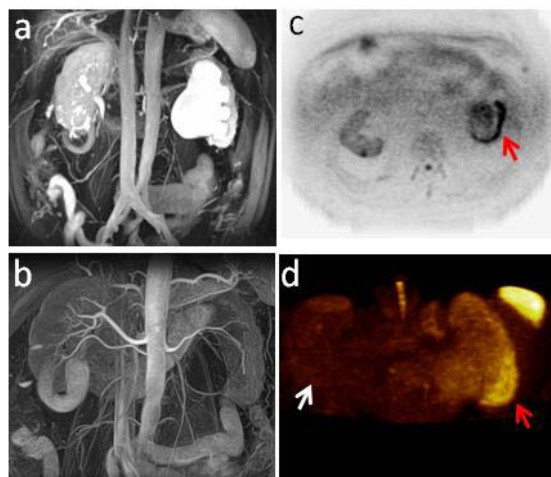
A 68 year old man with chronic renal insufficiency and left renal obstruction. The patient was treated for a prostate lesion. A SPECT scan revealed a non-functioning left kidney. (a) MIP image of the coronal SSFP image showing a serious pyelocaliectasis on the left kidney. (b) MIP image of the coronal Time-SLIP acquisition showing a single left renal artery and a single right renal artery and an inferior right polar artery with no abnormalities. (c) Axial slice of the Body diffusion image (inverted grey scale) showing an abnormal signal of the left kidney compared to the right kidney (see arrow). (d) Colour coded and reoriented MIP (coronal view) of the diffusion weighted image showing an abnormal hyper signal on the left kidney (red arrow) compared to the right kidney (white arrow).
